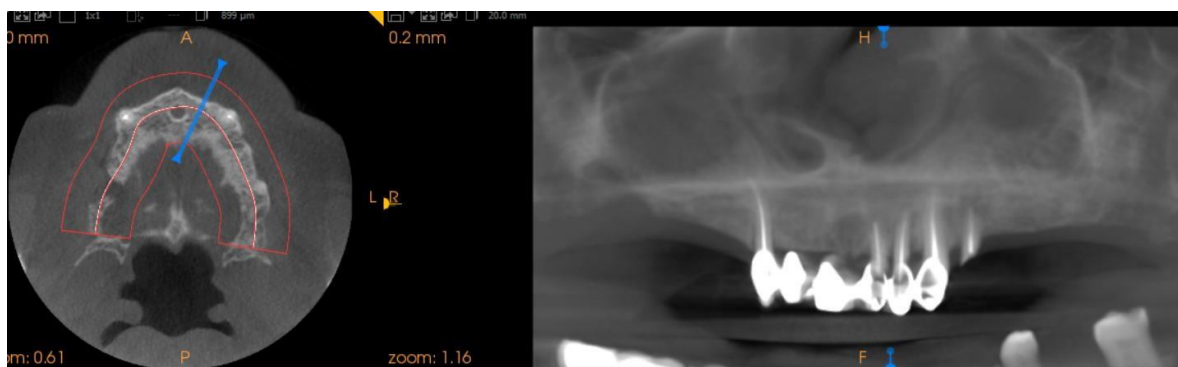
Treatment planning using CBCT
